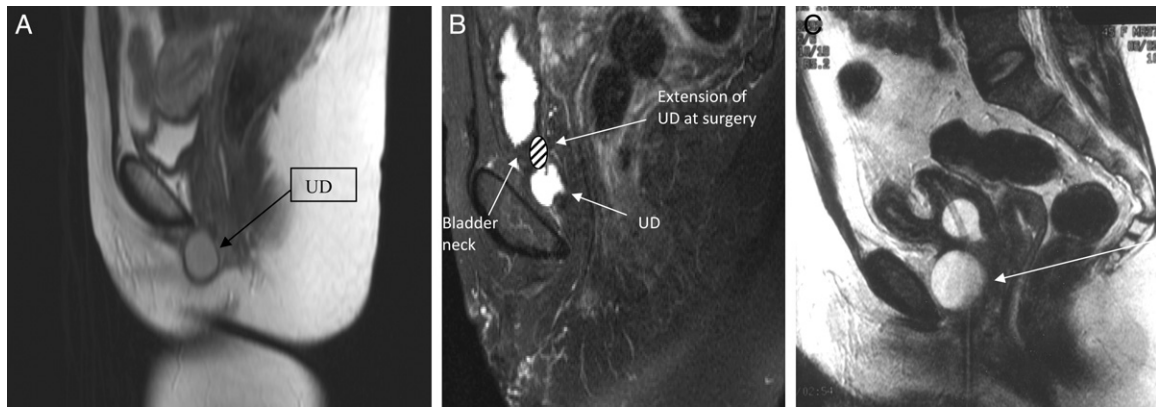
A, inaccurate UD diagnosis in patient 6 with UD diagnosed with Bartholin's cyst on MRI. At operation lesion looked like simple vaginal wall inclusion cyst 1 cm lateral and proximal to urethral meatus. It was easily noted, thick-walled and bluish-white. B, preoperative MRI reveals error in anatomy/position in patient with 4 cm multiloculated, thick UD spanning entire urethral length. MRI shows 2 cm C-shaped UD distal to bladder neck. C, failure to detect squamous cell carcinoma within diverticulum (arrow).
